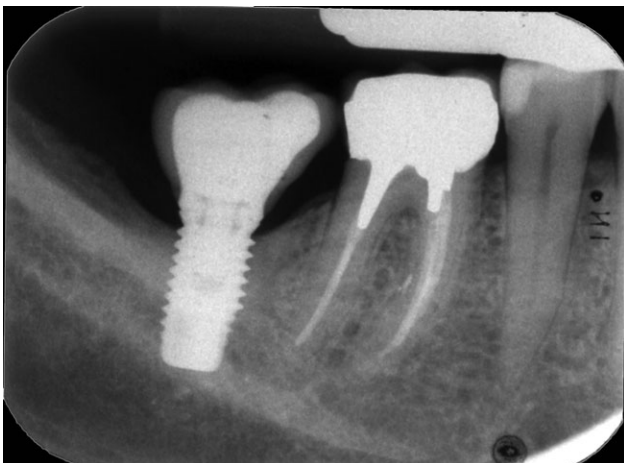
Baseline radiograph: bone crest up to platform level.
